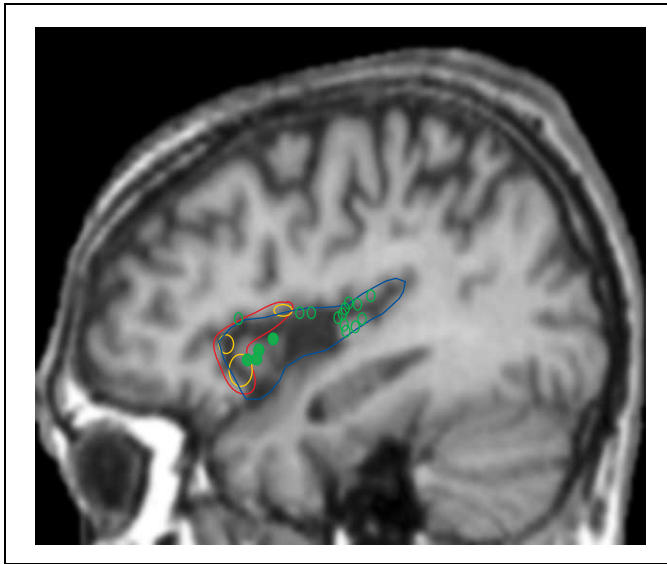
Sagittal T1-weighted anatomical MRI ($x = -36$) of patient NK [53] normalized to MNI space. The blue outline marks the zone of the left insular infarction. The red outline shows the zone we found to be activated during the experience of disgust; the yellow outline indicates those zones found to be common to this experience and the observation of someone else's facial expression of disgust [55]. The approximate location of the depth-electrodes of Krolak-Salmon *et al.* [51] are shown in green. Filled circles mark electrodes that showed selective responses to the sight of disgusted facial expressions.
